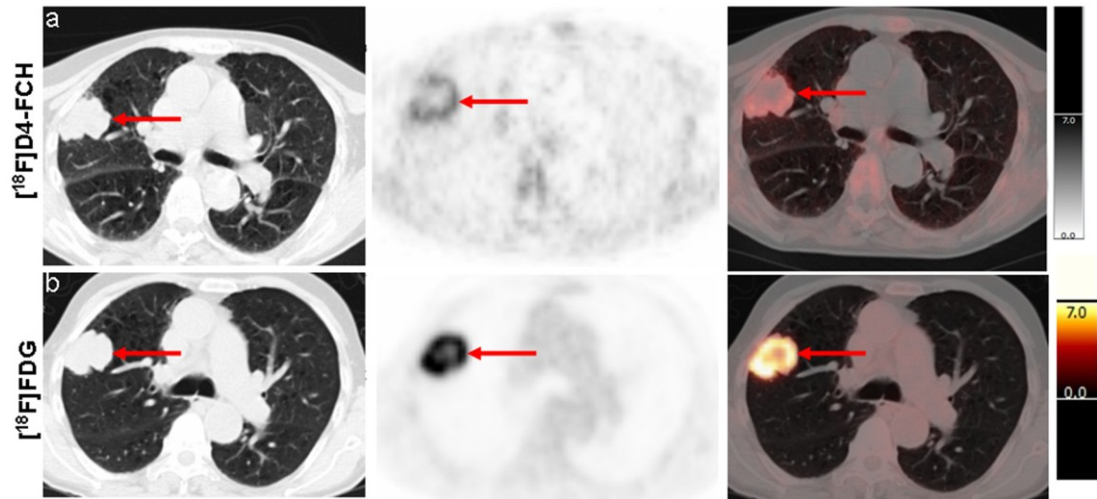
Axial slices of the CT, PET and fused PET/CT showing uptake of $[^{18}\text{F}]\text{D4-FCH}$ and $[^{18}\text{F}]\text{FDG}$ in a right upper lobe primary lung tumour in the same patient.
